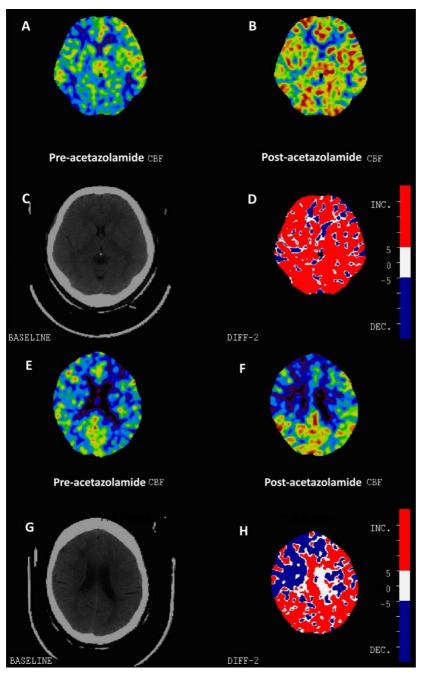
Xenon CT to assess cerebrovascular reserve capacity
